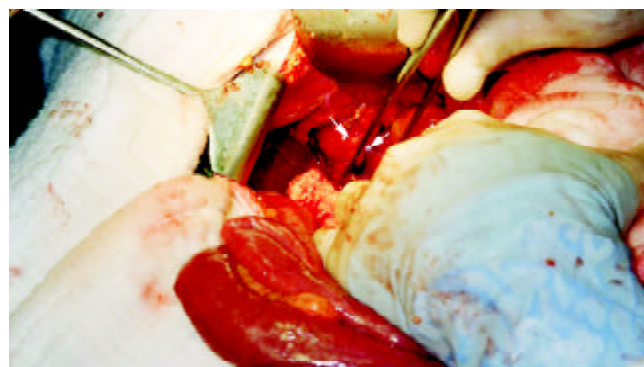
Intraoperative ultrasound revealed that the suspicious stone was in the gallbladder instead of the duodenal lumen.
